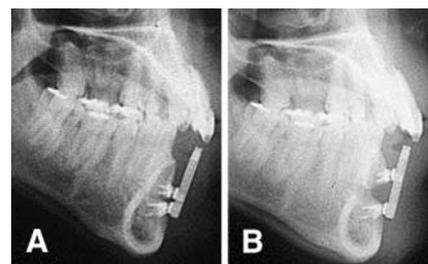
Maxillary X-ray teleradiographs of the dentulous patient at the beginning (A) and at the end of the distraction period (B). The setting of the distraction vector is virtually unchanged.
